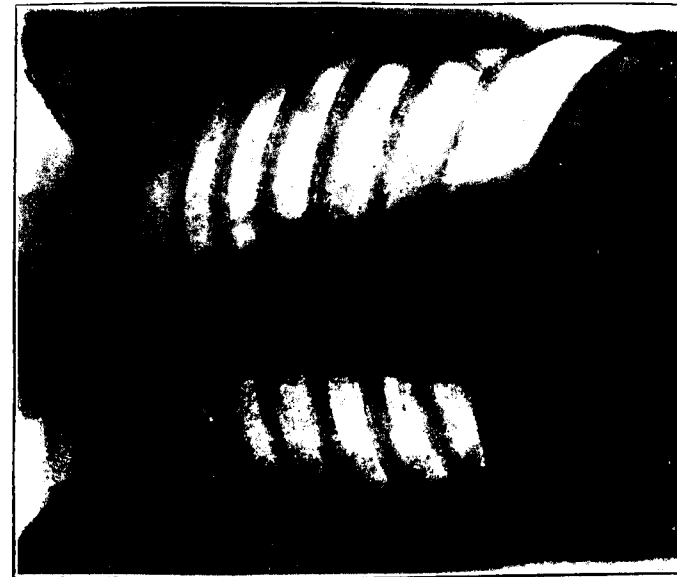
Same case as Fig. 6. X-ray taken a year later. Note that the diaphragm has recovered and come back to normal position.
